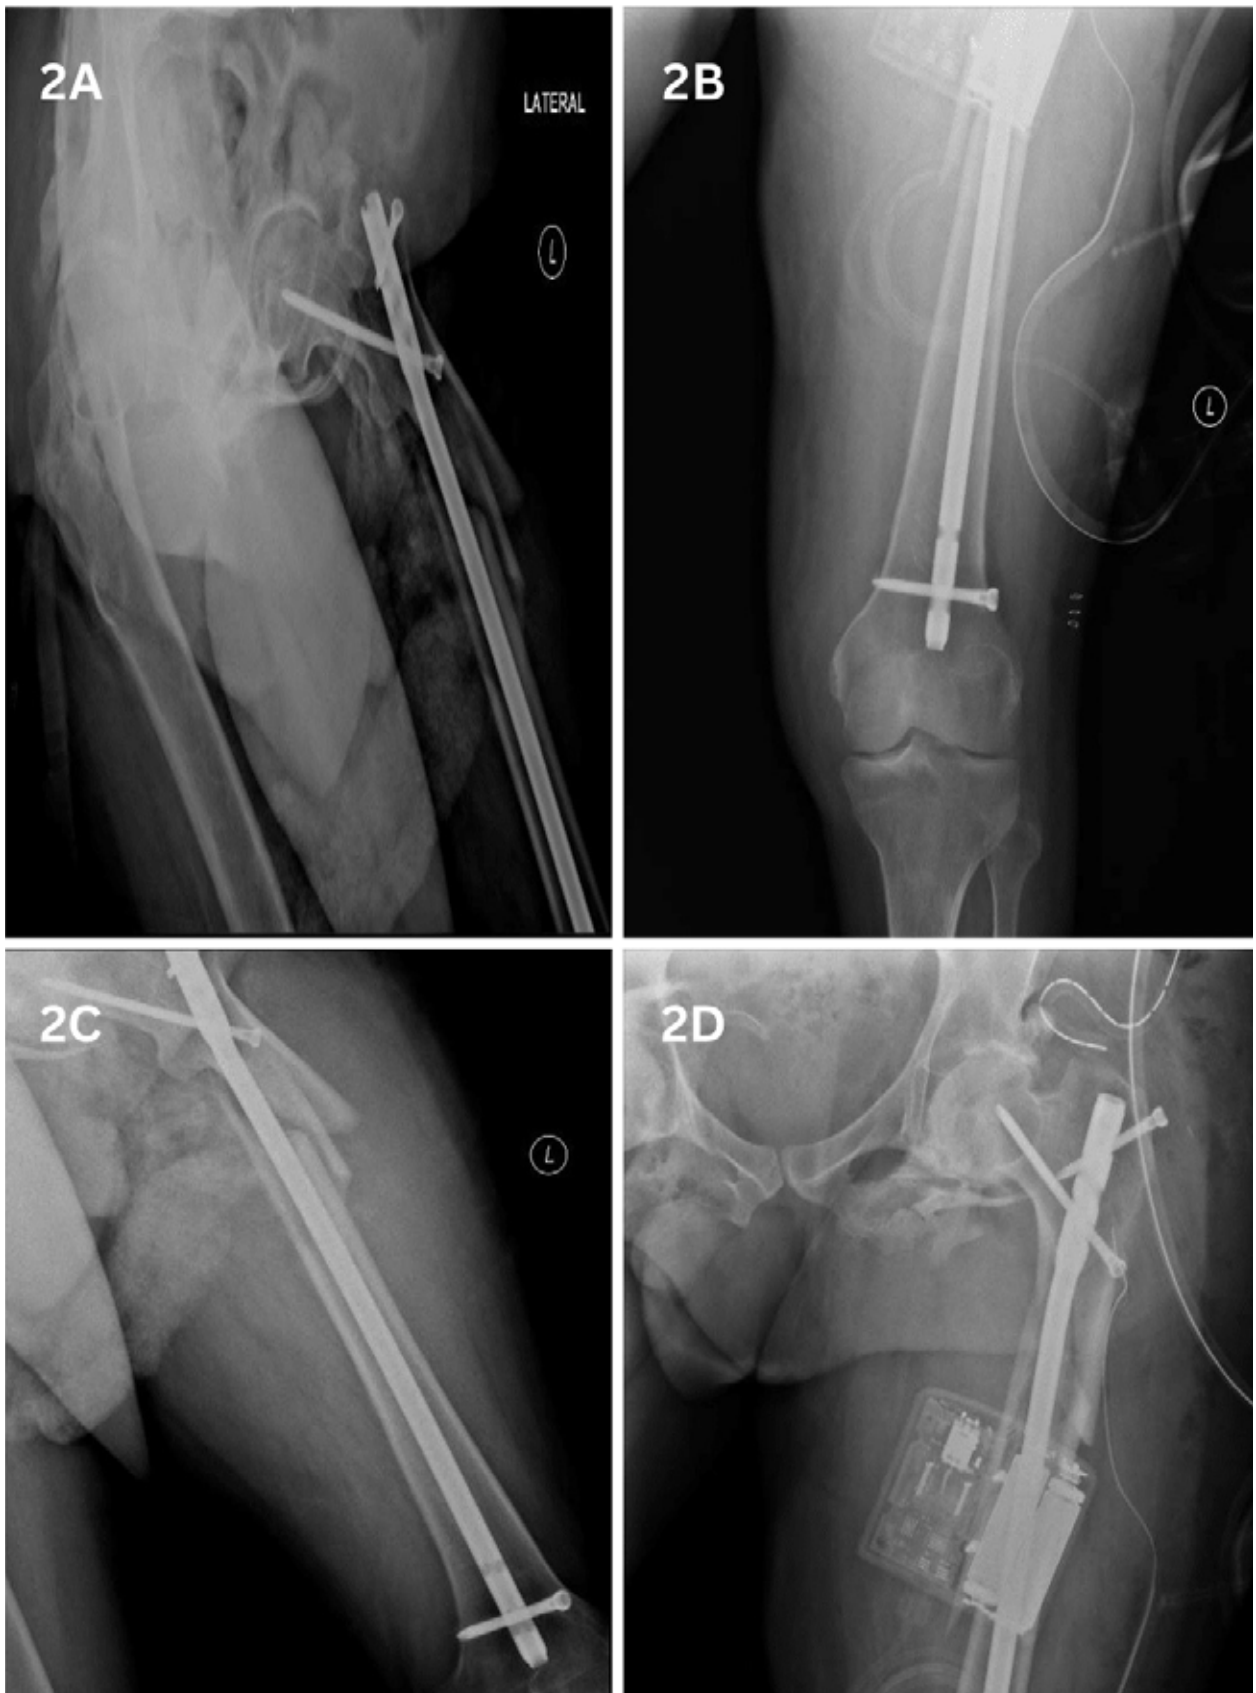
(A-D): Immediate postoperative x-ray
